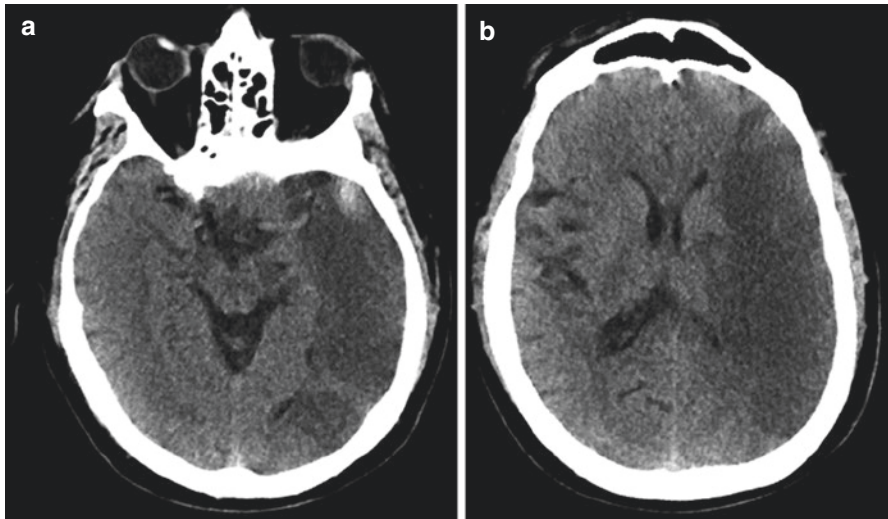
Admission head CT showing a possible hyperdense left MCA sign (a) and early infarct characterized by sulcal effacement and loss of gray-white junction (b)
